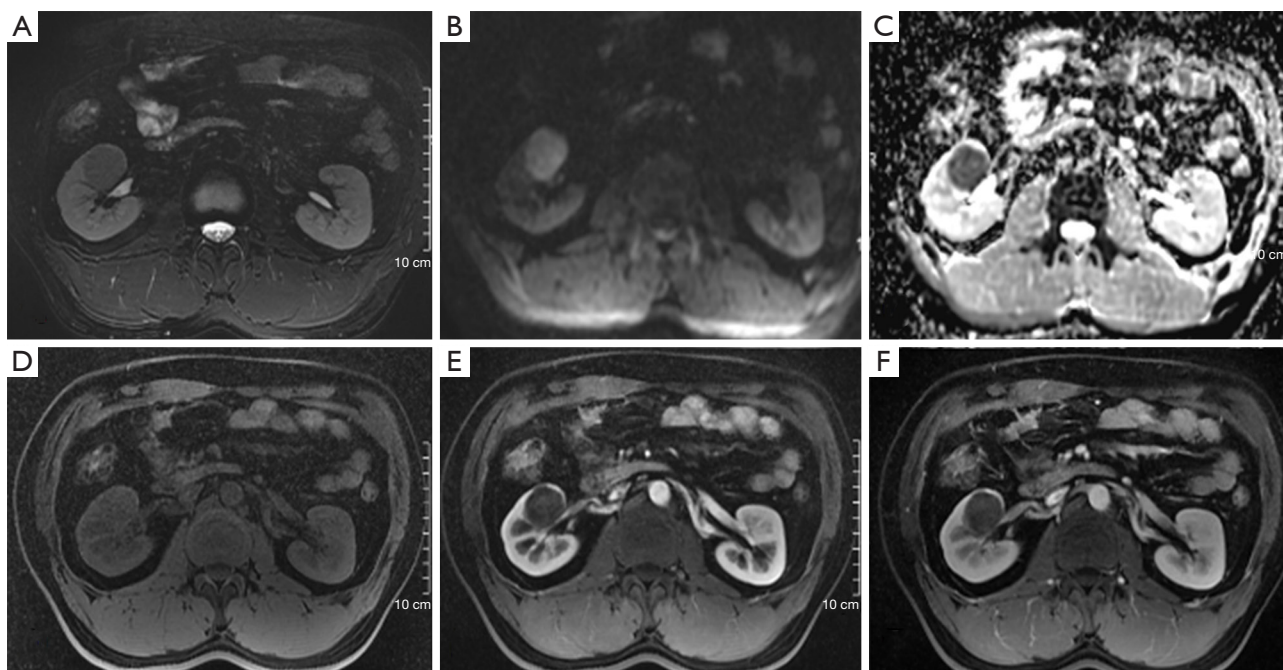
Magnetic resonance images from the patient. (A) Axial fat-suppressed T₂WI showing a homogeneous and notably hypointense 3.5 cm × 3.0 cm mass in the mid-portion of the right kidney. (B) Diffusion-weighted imaging ($b = 1,000 \text{ s/mm}^2$) showing a homogeneous high signal. (C) ADC imaging showing a homogeneous low signal. (D) Axial fat-suppressed T₁-weighted imaging showing a small, round, isosignal external mass. (E) Corticomedullary phase imaging showing mild homogeneous enhancement inside the mass. (F) Nephrographic phase imaging showing slightly gradual enhancement. T₂WI, T₂-weighted imaging; ADC, apparent diffusion coefficient.
